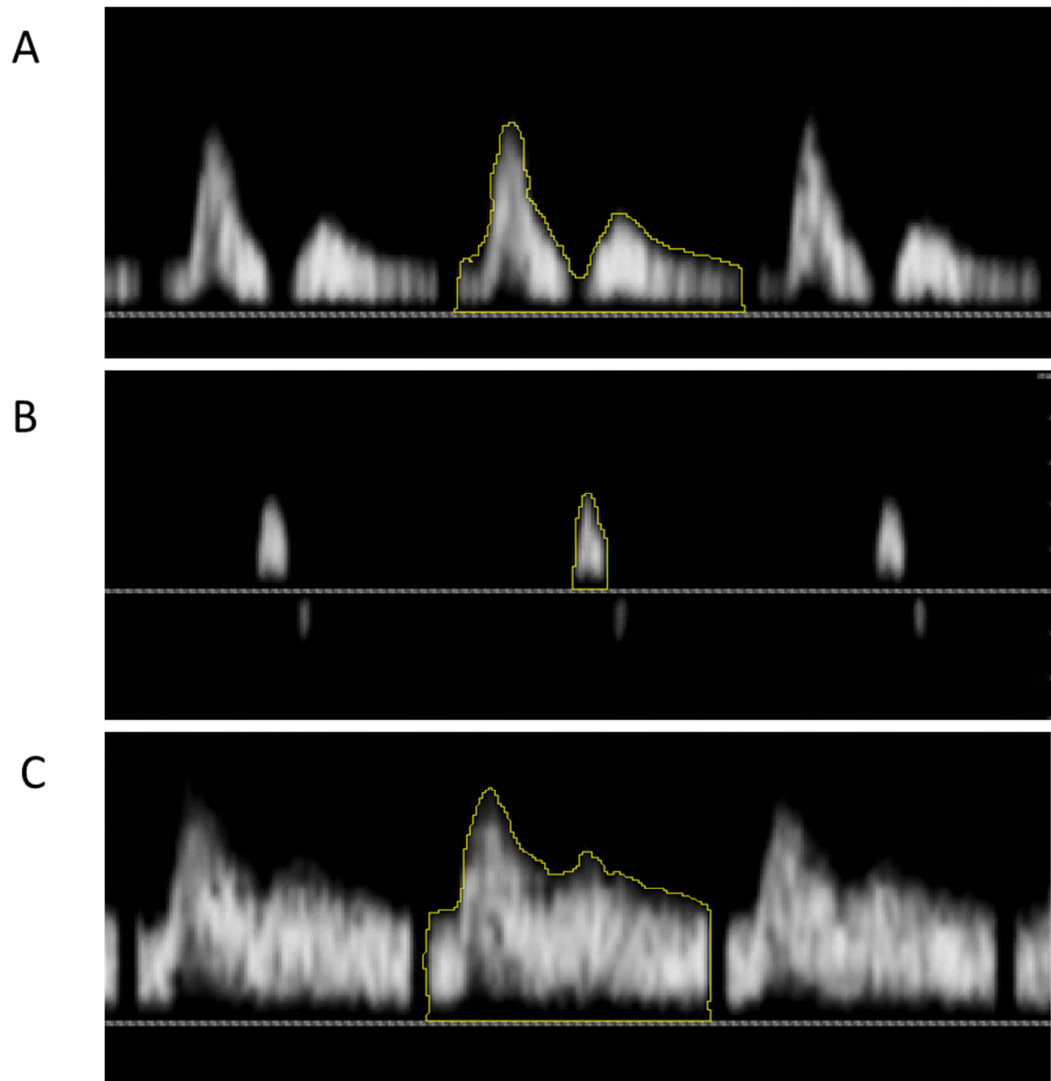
Image analysis technique for velocity-time integral assessment. Representative image is shown of the Doppler velocity-time envelope in the brachial artery. Profiles were displayed for each cardiac cycle during flow mediated dilatation recording. Imaging software was used to free-hand (yellow line) outline the envelope during rest (baseline, A), distal cuff occlusion (low flow, B), and following cuff release (high flow, C). Area under the curve measurements were expressed as the velocity-time integral (VTI) in meters.
